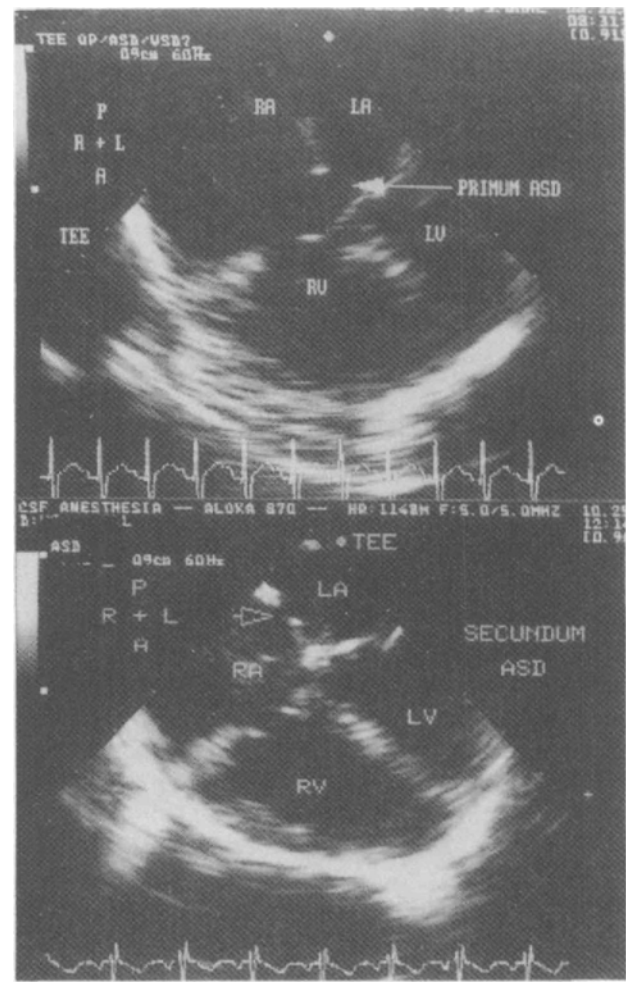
Interatrial communication viewed from the transoesophageal four-chamber view. Each is indicated by an arrow in the respective figure. Top: ostium primum atrial septal defect (ASD). Bottom: ostium secundum ASD. RA = right atrium; LA = left atrium; RV = right ventricle; LV = left ventricle. (Reproduced with permission from Muhiudeen *et al.*: Intraoperative echocardiography for evaluation of congenital heart defects in infants and children. *Anesthesiology* 1992; 76: 165-72.)
